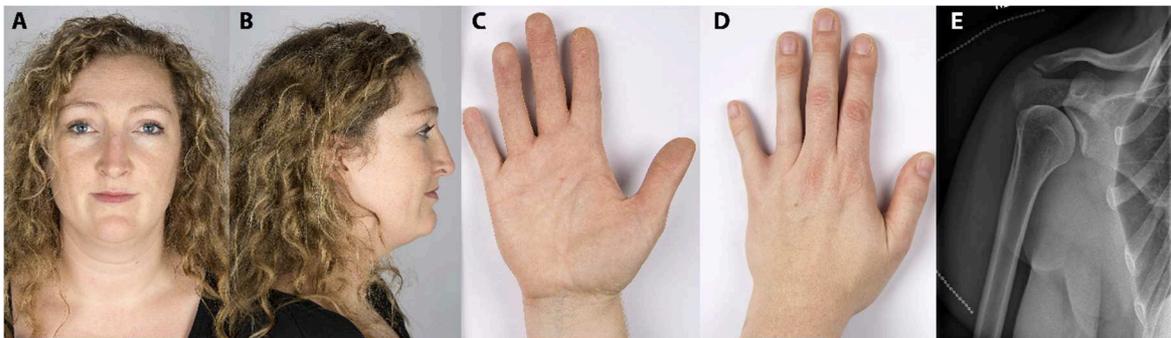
Clinical findings in patient 3. Facial features (A,B), hand malformations with visible lack of flexion crease at 4th and 5th PIP (C,D) and the x-ray of the shoulder (E) with deformed glenoid cavity.
